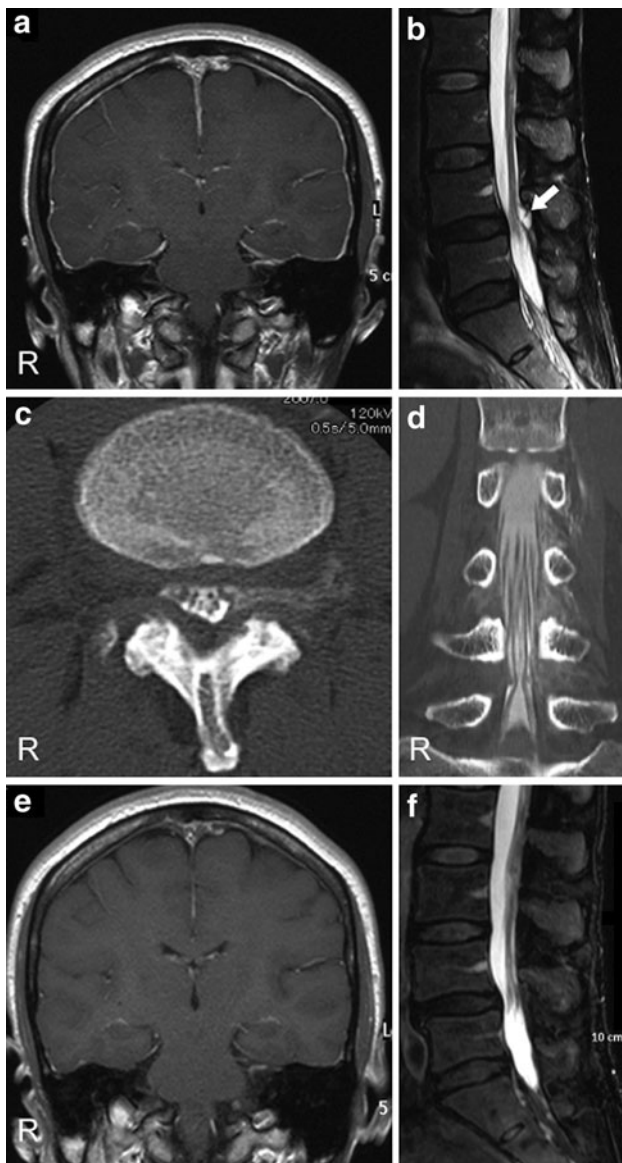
a Coronal gadolinium-enhanced T1-weighted cranial MRI revealing PMGE and enlargement of the venous sinuses. b Sagittal T2-weighted lumbar MRI showing L4–5 spondyloisthesis. An abnormal hyperintensity is noted back to the same level (*arrow*). c Axial CT myelogram at the L4–5 level showing CSF leakage on the left side. d Coronal reconstruction image of CT myelogram findings of the lumbar region showing extensive CSF leakage. e Coronal gadolinium-enhanced T1-weighted cranial MRI 1-month later revealing disappearance of PMGE and enlargement of venous sinuses. f Sagittal T2-weighted lumbar MRI 5 months after discharge showing the disappearance of abnormal hyperintensity. *R* right side
